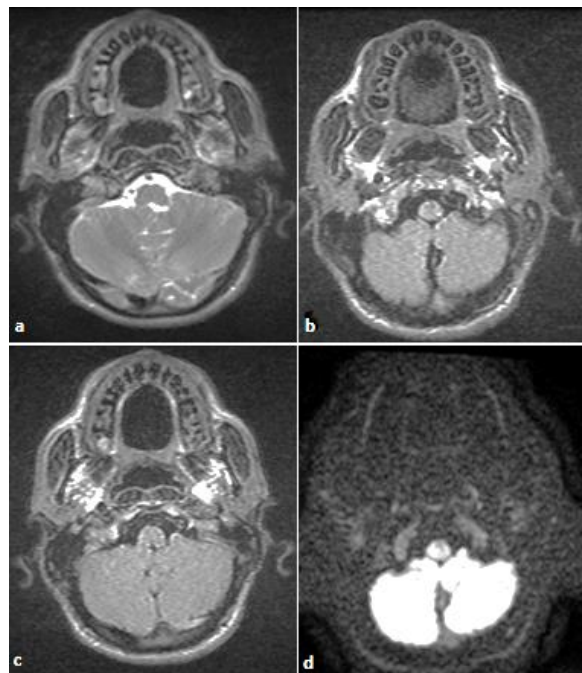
MRI showing no cerebellum abnormalities in T2WI (a), FLAIR (b,c) and DWI sequences (d)
